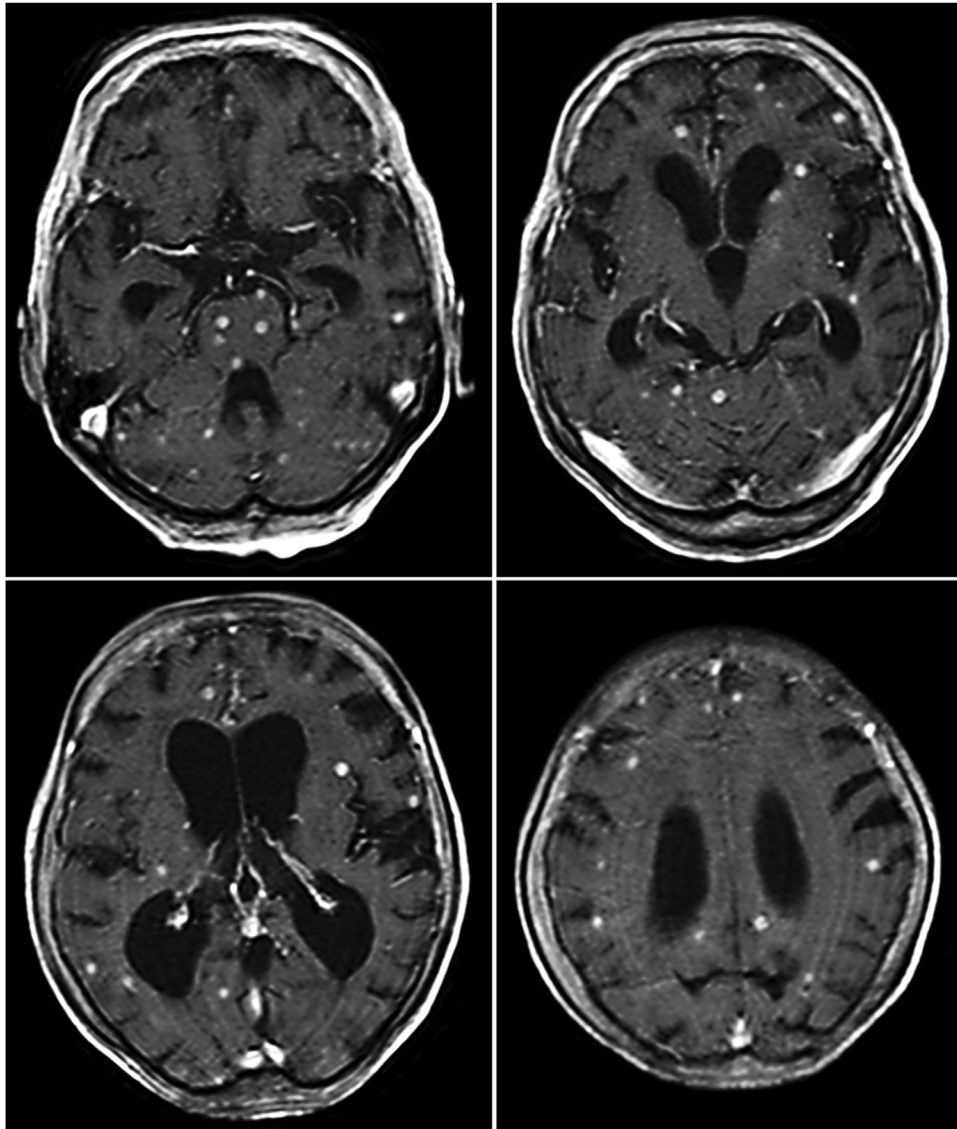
Axial view of T1-weighted gadolinium-enhanced magnetic resonance images showing multiple enhancing lesions in both the cerebral and cerebellar hemispheres and pons, suggestive of tuberculomas.
